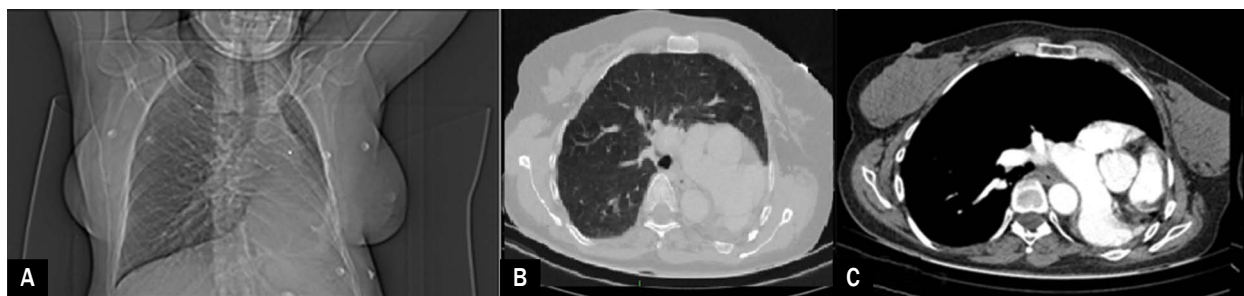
Contrast-enhanced thorax computed tomography: A. The patient's left lung was hypoplastic, mediastinum shifted to the left; B. Hypertrophy findings and areas of emphysema were observed in the right lung; C. Upper lobe of right lung extended and located to the upper part of the left-sided lung space
